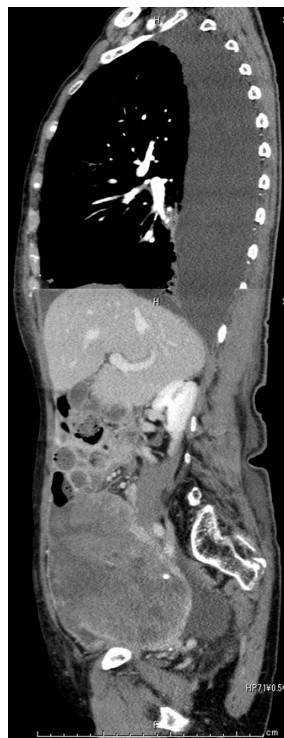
A whole-body CT showing pleural effusion, slight ascites and a huge uterine mass.
